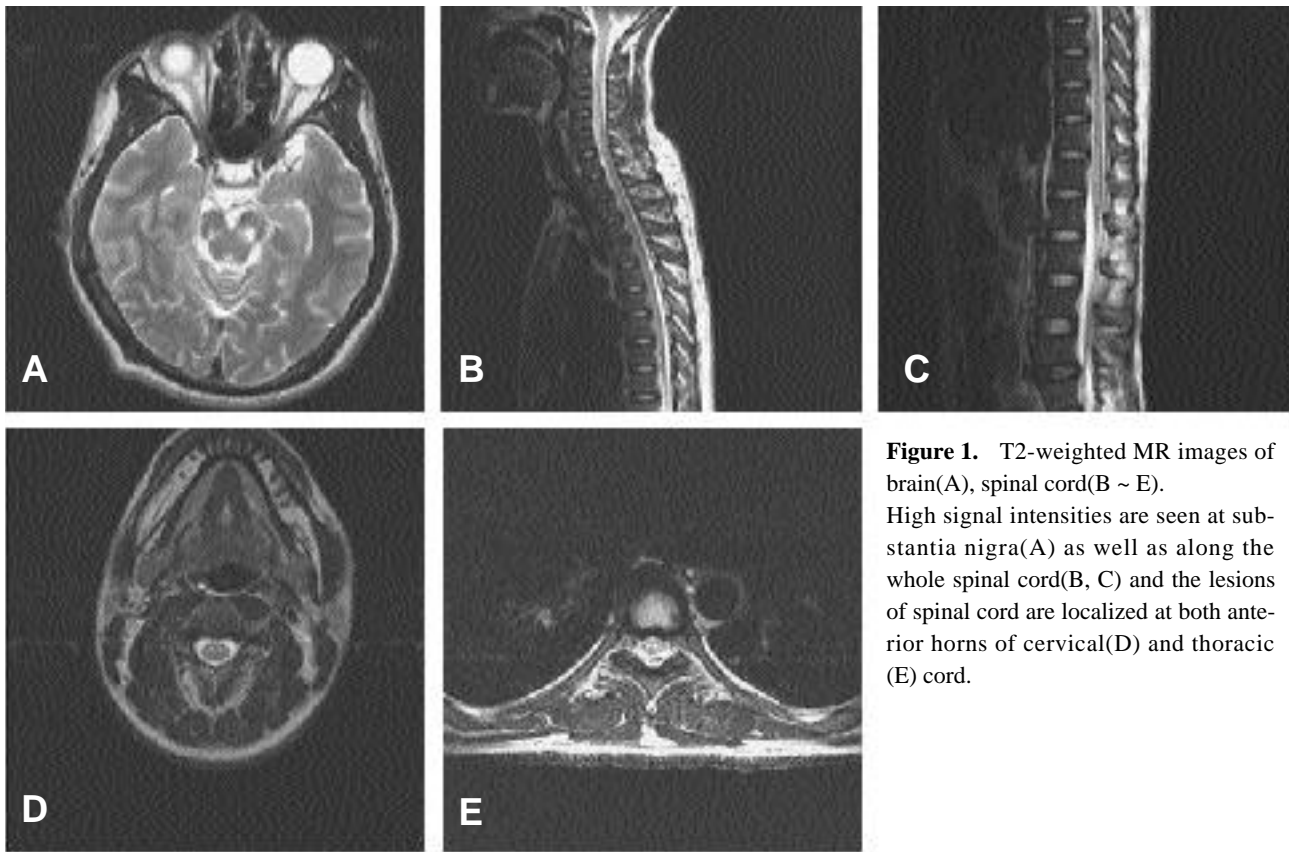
T2-weighted MR images of brain(A), spinal cord(B ~ E). High signal intensities are seen at substantia nigra(A) as well as along the whole spinal cord(B, C) and the lesions of spinal cord are localized at both anterior horns of cervical(D) and thoracic (E) cord.
